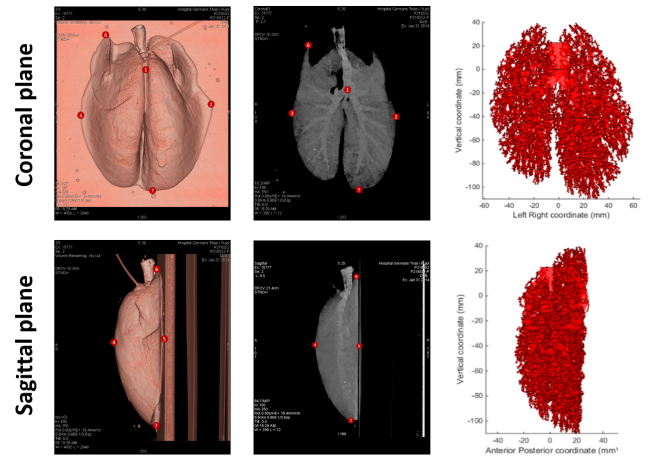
CT data of a minipig pulmonary surface (left and center), and the corresponding virtual bronchial tree (right).
